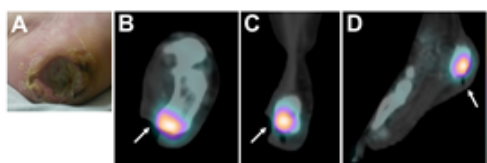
^{99m}Tc-methylene diphosphonate (MDP) SPECT/CT imaging of osteomyelitis in a lower extremity wound. A) A patient presenting with a deep non-healing heel wound. B) Axial, C) coronal, and D) sagittal views of ^{99m}Tc-MDP SPECT/CT imaging of the foot revealed the presence of osteomyelitis localized to the wound site.
